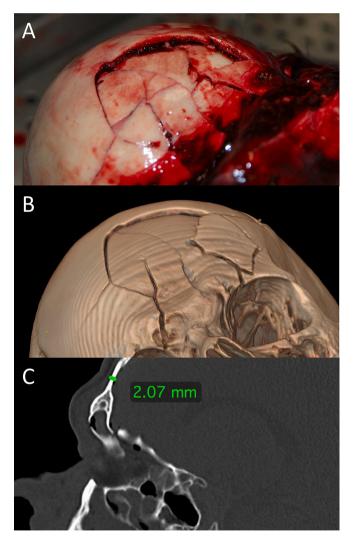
Depressed frontal fracture. Note the extreme thinness of the cranial vault. A) autopsy finding, B) 3D reconstruction, C) CT measurement.
